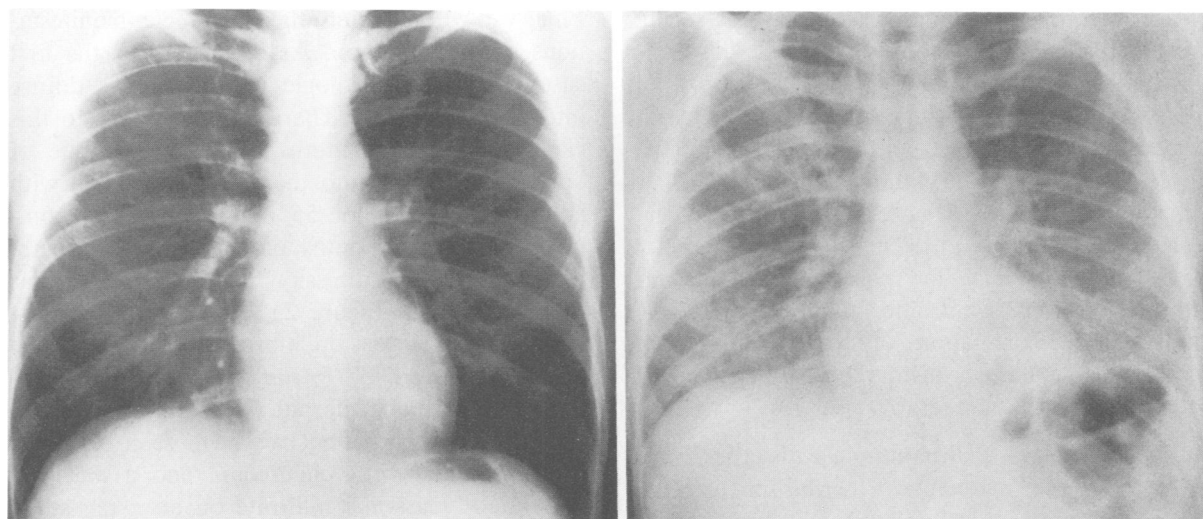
Left, Normal chest x-ray study of a patient with an oxygen tension of 55 mm of mercury taken at the time a bronchoscopic examination that was positive for *Pneumocystis carinii* pneumonia. Right, X-ray film taken four days after initial normal film showing rapid progression of pneumonia.
